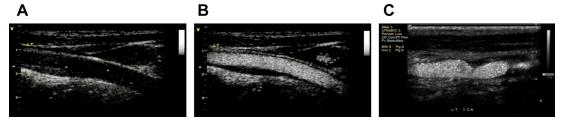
Contrast-enhanced ultrasonography (CEUS) detection of carotid atherosclerotic plaques. (*A*) An unenhanced ultrasonography image of the common carotid artery, in which the plaque is faintly visible. (*B*) CEUS image of the same vessel, highlighting the presence of the plaque without significant luminal stenosis (positive remodeling). (*C*) CEUS image of the internal carotid artery showing intrusion of the vessel lumen of the plaque resulting in luminal narrowing (negative remodeling).
